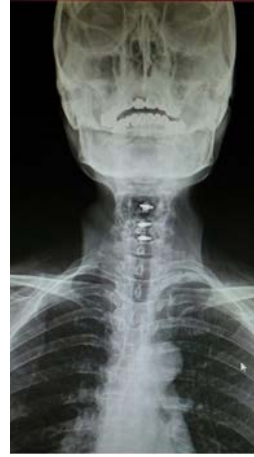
Postoperative anterior and posterior direct radiograph of C4-5, C5-6, and C6-7 bladed cage.
